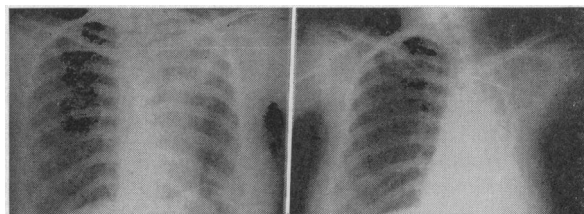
Left*: Roentgenogram (Nov. 24, 1947) showing atelectasis of the left upper lobe. *Right*: (Dec. 22, 1948) An anatomically satisfactory thoracoplasty but also atelectasis of the entire left lung.
